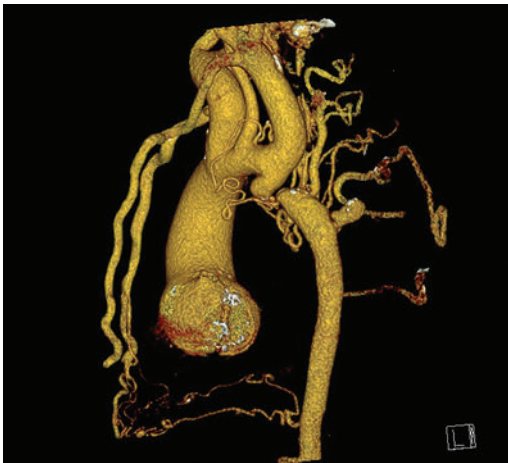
CT-scan showing a bicuspid aortic valve and a dilated aortic root (58 mm). Aortic isthmus atresia with a 3-4 mm gap between the distal aortic arch and the thoracic aorta may be seen. There are multiple collaterals between the upper and lower part of the body.
